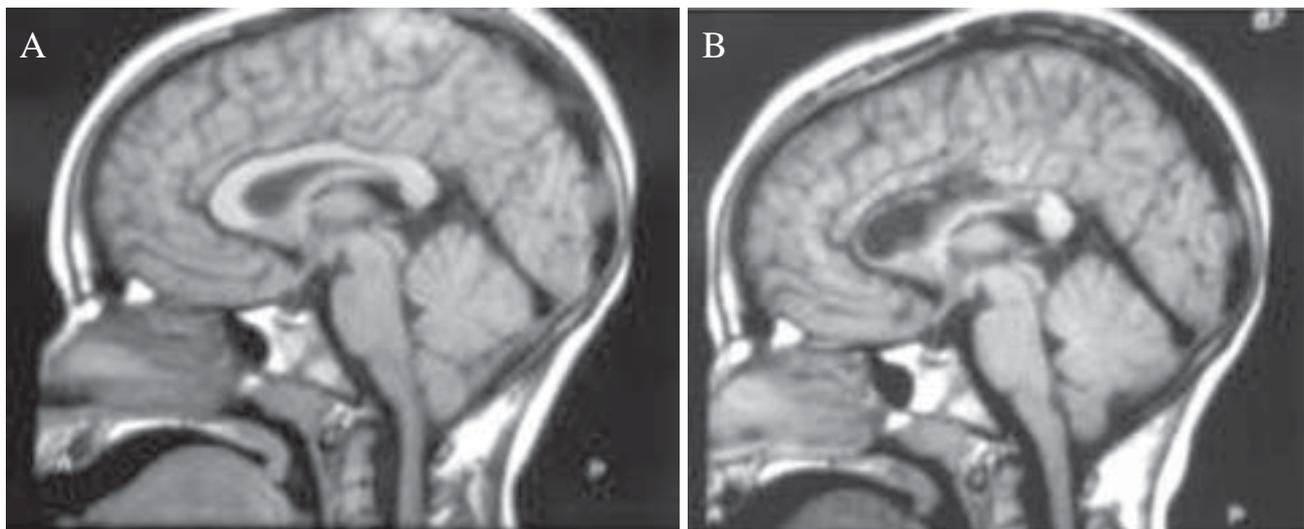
Ten-year-old child with mental retardation and atonic seizures. (A) Preoperative, mid-sagittal MRI demonstrating intact corpus callosum. (B) Postoperative image following anterior two-thirds resection of corpus callosum.
